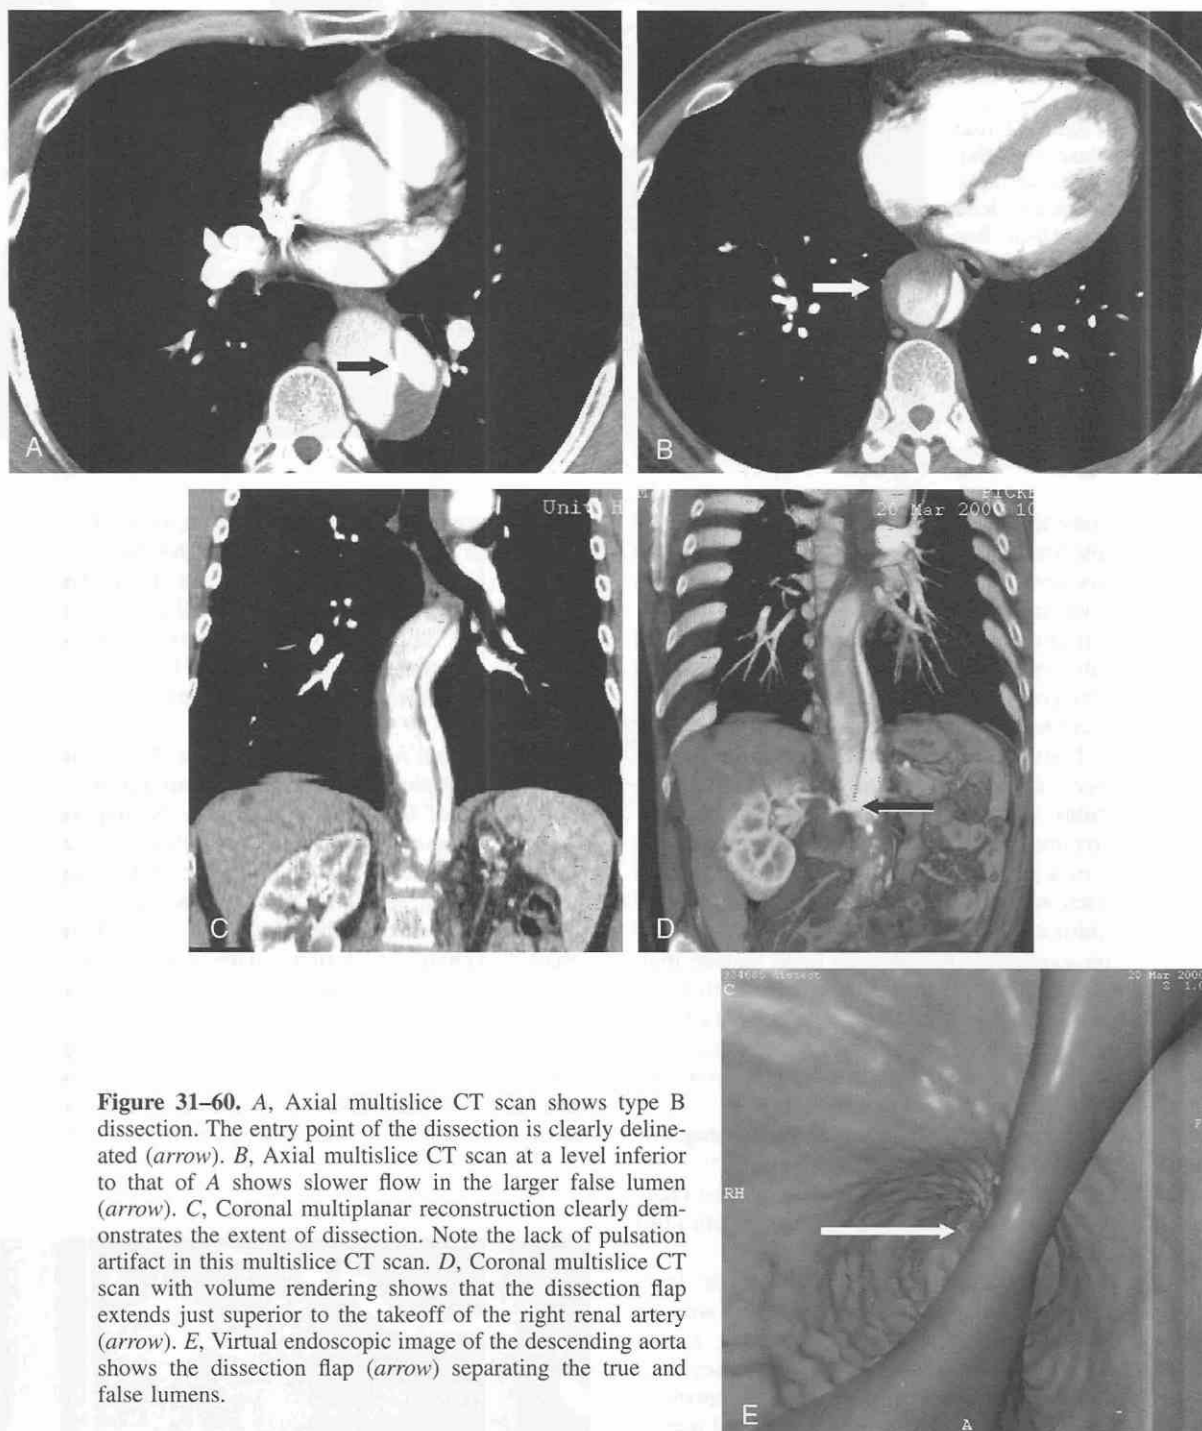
A, Axial multislice CT scan shows type B dissection. The entry point of the dissection is clearly delineated (arrow). B, Axial multislice CT scan at a level inferior to that of A shows slower flow in the larger false lumen (arrow). C, Coronal multiplanar reconstruction clearly demonstrates the extent of dissection. Note the lack of pulsation artifact in this multislice CT scan. D, Coronal multislice CT scan with volume rendering shows that the dissection flap extends just superior to the takeoff of the right renal artery (arrow). E, Virtual endoscopic image of the descending aorta shows the dissection flap (arrow) separating the true and false lumens.
